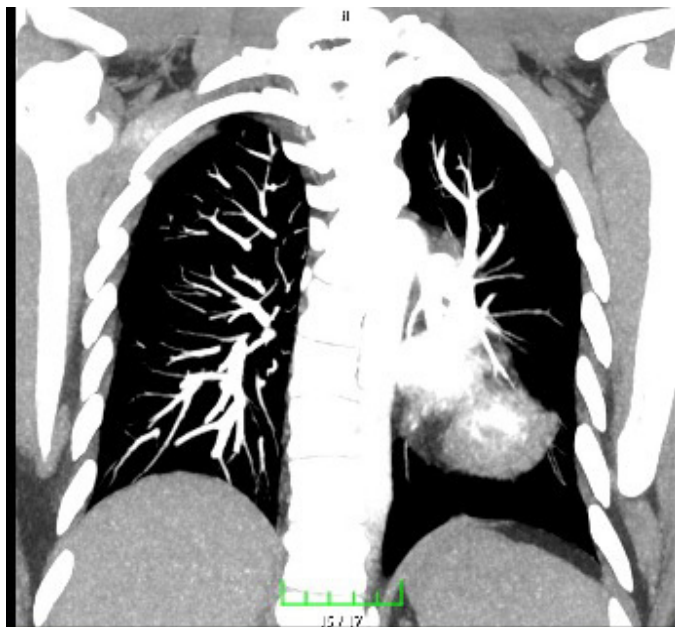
Compensatory increase in the right air spaces was observed in the patient's pulmonary computed tomography angiography
